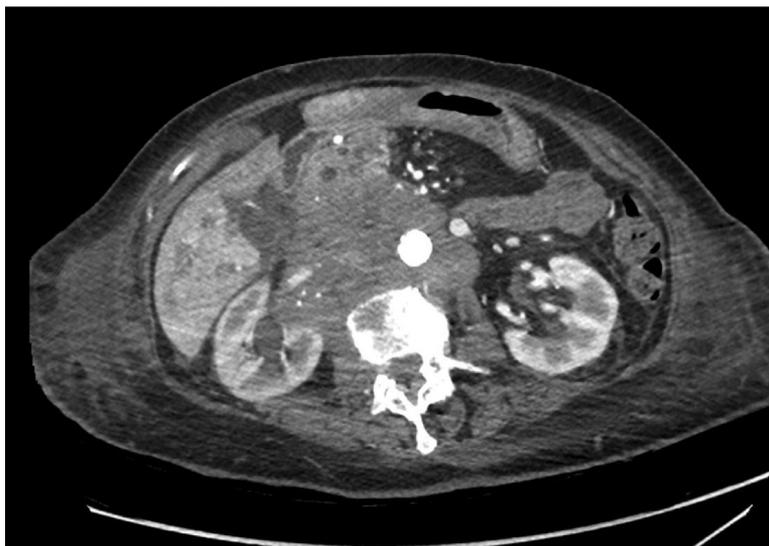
Primary pancreatic lymphoma in 82-year-old female patient. Axial contrast enhanced CT image shows a hypoattenuating infiltrative mass infiltrating the pancreatic head, the retroperitoneal right perirenal space and surrounding the abdominal aorta.
